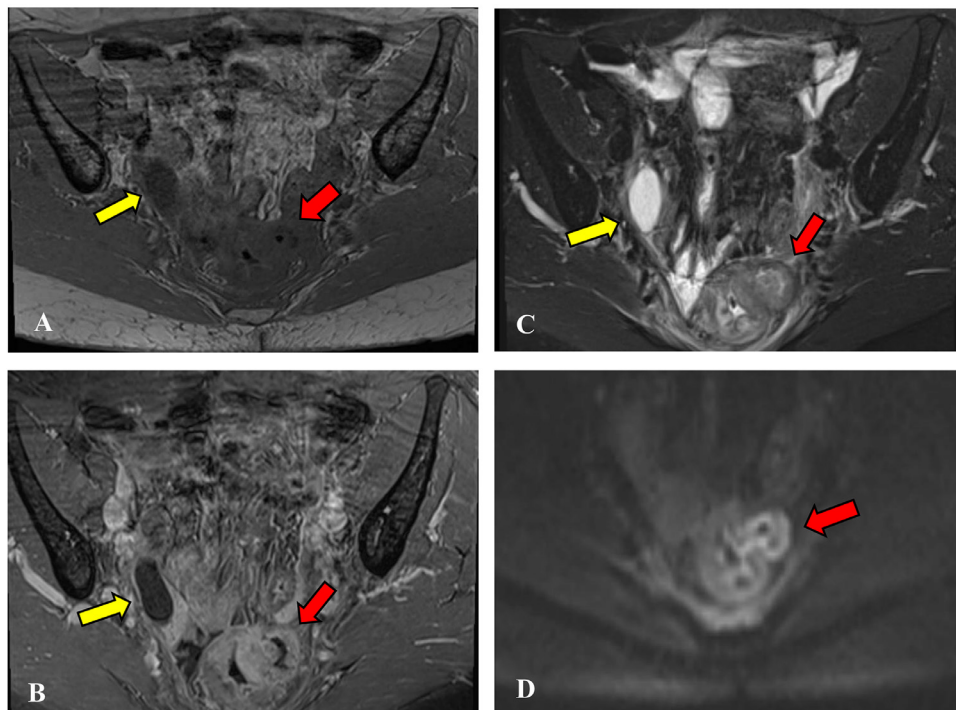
MRI pelvis (A: T1 weighted precontrast image, B: T1 weighted postcontrast image) indicating complex left-sided perirectal hypointense mass at the level of mid-rectum with infiltration into the rectum (red arrow) and a separate lesion along the right-sided pelvic sidewall (yellow arrow). (C) shows a T2 weighted image of the MRI pelvis showing hyperintense irregular left-sided peri-rectal mass (red arrow) and a separate lesion on the right pelvic side wall (yellow arrow). (D) is a diffusion-weighted imaging (DWI) sequence of MRI pelvis showing hyperintense irregular peri-rectal mass with restricted diffusion (red arrow), concerning recurrent vaginal cancer with rectal involvement.
